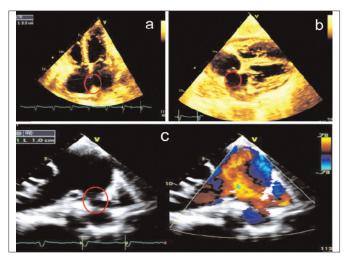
Echo images (a,b) show atrial septal defect as marked with the red circle; echo image (c) shows without and with colour doppler images of patent ductus arteriosus as marked with the red circle.
